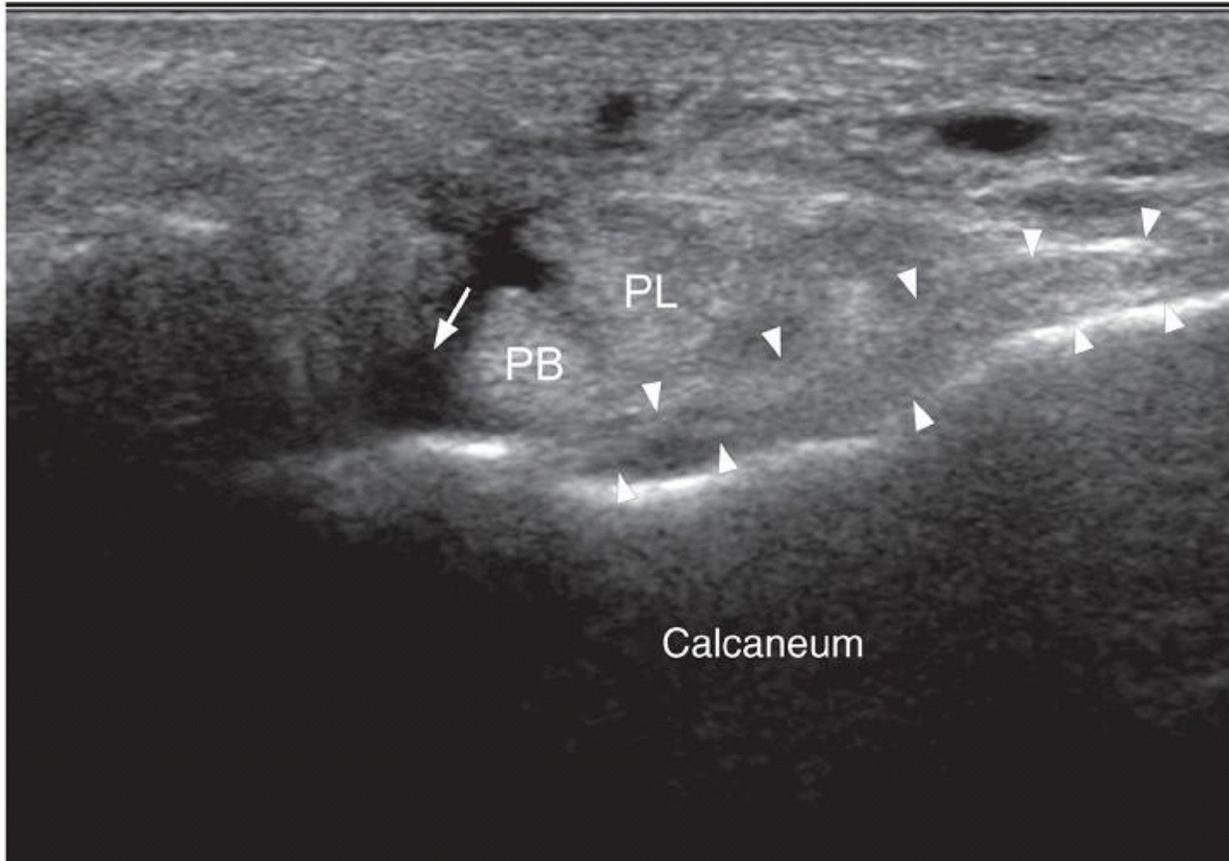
Longitudinal ultrasound of the lateral inframalleolar region. There is a complete tear (arrow) of the CFL from its fibular attachment. The torn ligament (arrowheads) has lost its normal “hammock effect” and is lying against the calcaneum deep to the peroneus longus (PL) and peroneus brevis (PB) tendons.
